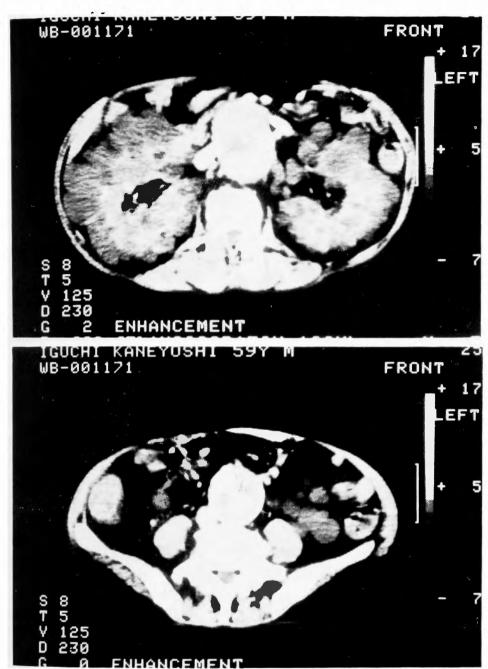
Abdominal CT showing abdominal aneurysm and polycystic kidneys
